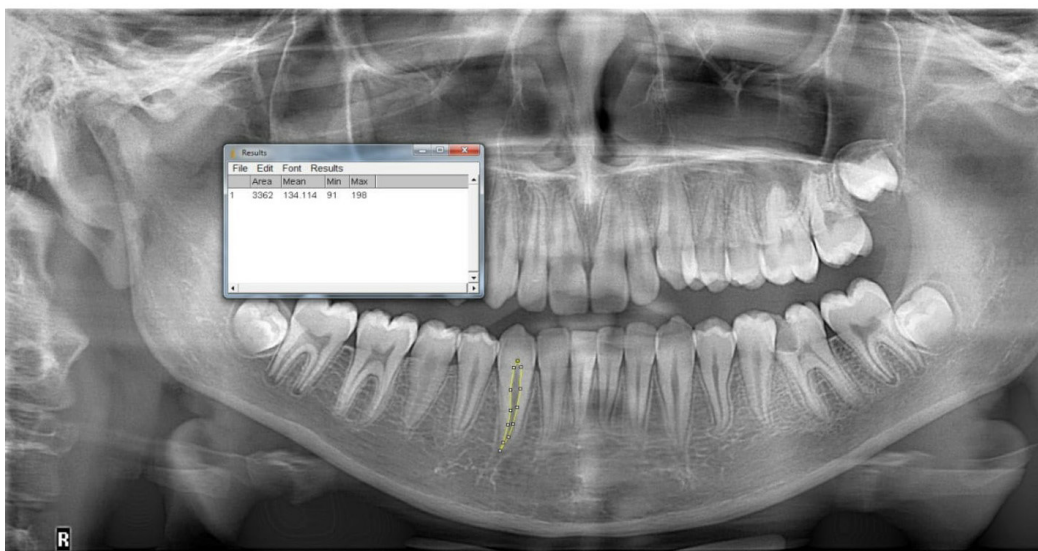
Measurements of Pulp Area on the Radiograph
